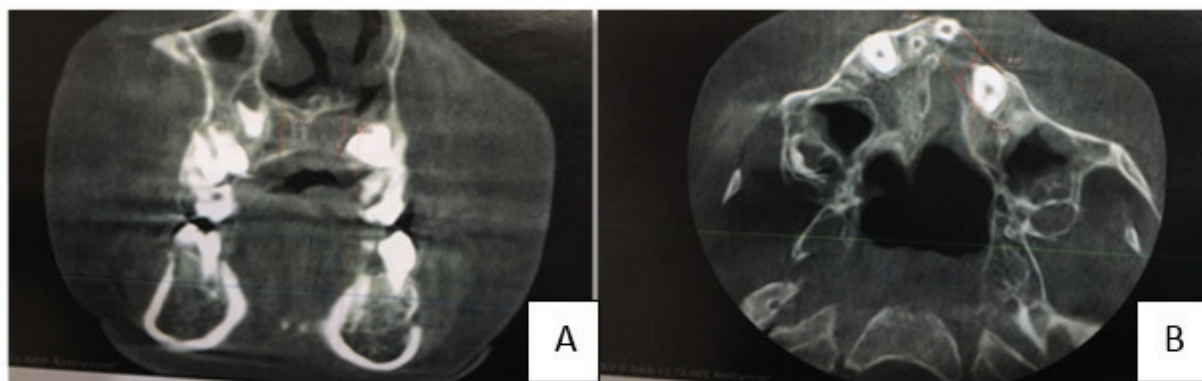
A. Coronal view and B. Axial view of CBCT 6 months postoperatively
